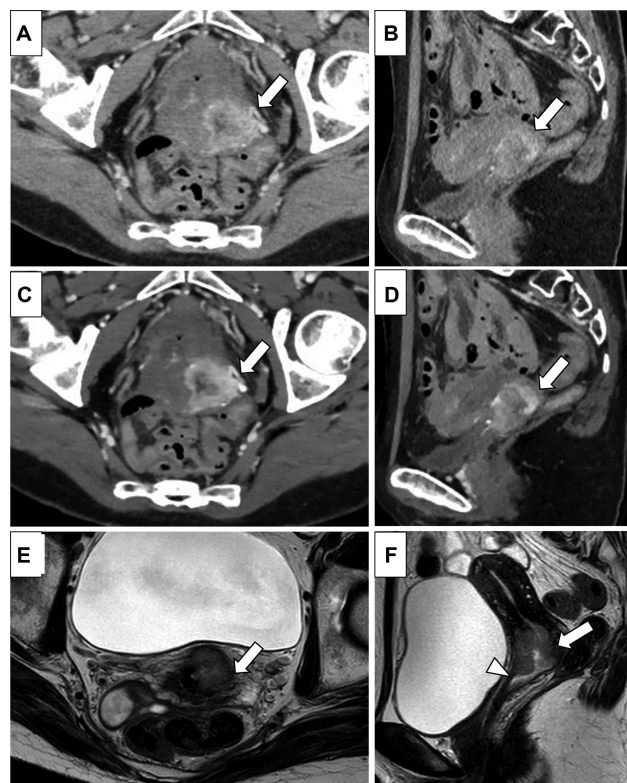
A 56-year-old female patient with cervical cancer (squamous cell carcinoma), pathologically diagnosed with International Federation of Gynecology and Obstetrics (FIGO) 2018 IIA1. (A, B) Conventional computed tomography (C-CT) axial, sagittal images. (C, D) Virtual monoenergetic image (VMI) axial, sagittal images. (E, F) T2-weighted image (T2WI) axial, sagittal images. The tumor is strongly enhanced, predominantly at the margins on C-CT (A, B; arrows). On VMI, the tumor enhancement effect is stronger, and its margins are more clearly defined (C, D; arrows). The preserved outer rim of cervical stroma on T2WI indicates no parametrial invasion (E; arrow), and the tumor reaches the upper edge of the anterior vaginal wall (F; arrowhead). On C-CT, one reader failed to detect the tumor. On VMI, three readers overdiagnosed with extension to the pelvic wall, but three readers correctly diagnosed the upper two-third vaginal involvement. On magnetic resonance imaging (MRI), only half of the readers correctly diagnosed lateral and vaginal invasion.
